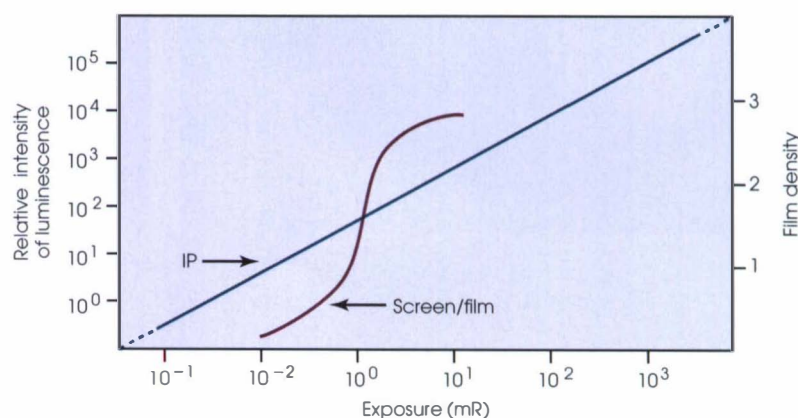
Comparison of radiographic film H&D response curve to linear plate response.
